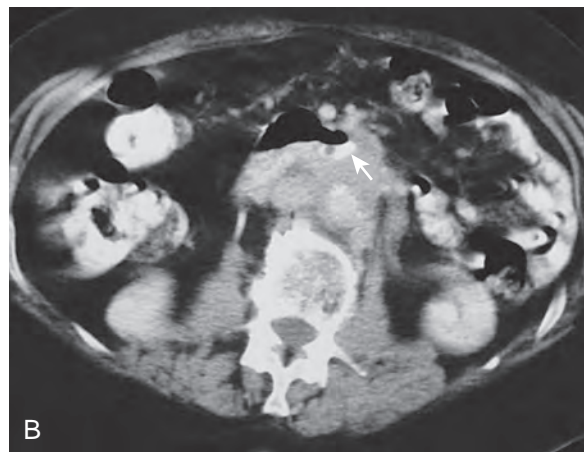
Duodenal invasion by retroperitoneal adenopathy. A. Barium study shows an ulcerated lesion (arrow) at the junction of the third and fourth portions of the duodenum. B. CT scan reveals a conglomerate mass of para-aortic adenopathy encasing the distal duodenum with associated ulceration (arrow).
